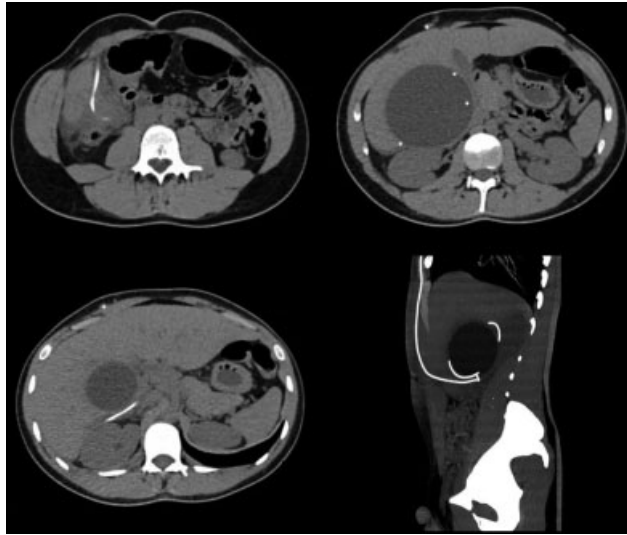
Abdominal computed tomography scan showing an hepatic pseudocyst of intracapsular cerebrospinal fluid, due to the probable entry of the distal ventriculoperitoneal shunt catheter through the hepatic capsule
